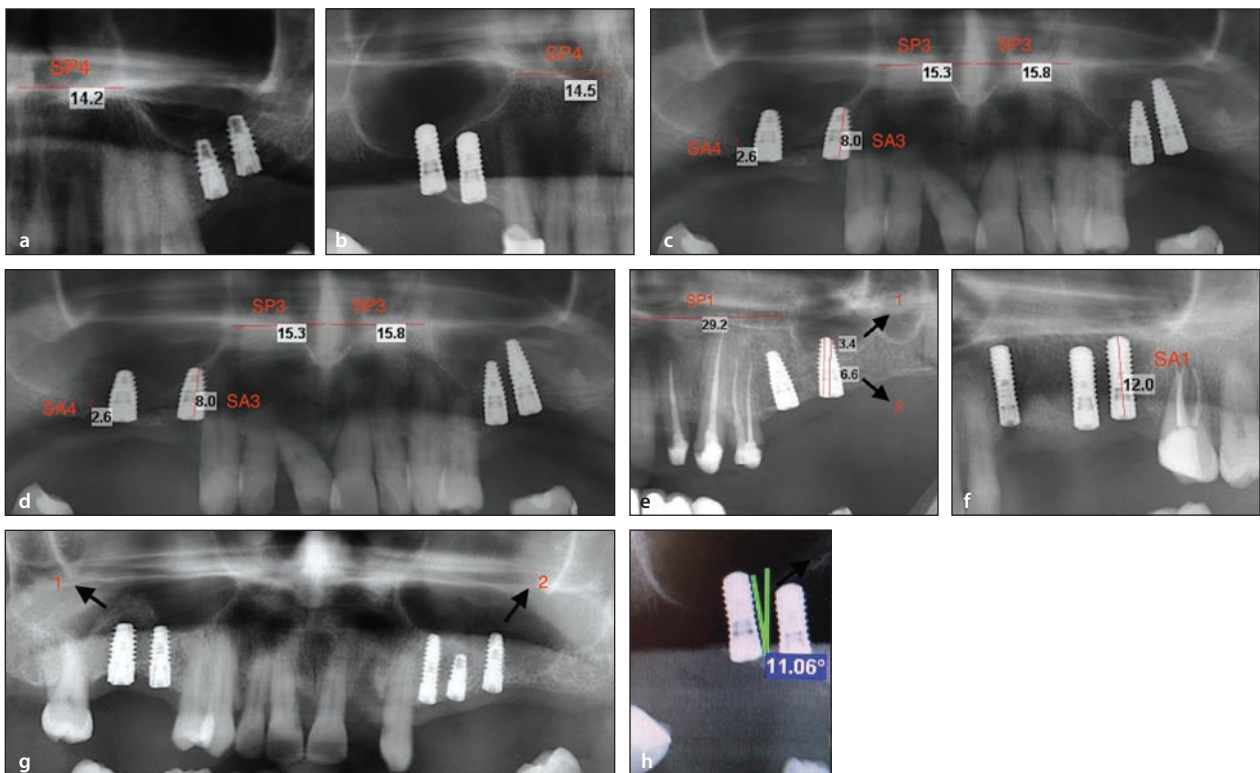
Inferior pneumatization of maxillary sinus and medial pneumatization of maxillary sinus are shown; the measurements (in millimeters) of the dental implants in bone and sinus were made from panoramic radiographs. (a) SA4 classification. (b) SA4 classification. (c) SP2, SP3, and SA2 classifications in the same patient, length measurements for dental implants. (d) SP3, SA3, and SA4 classifications in the same patient, length measurements for dental implants. (e) SP1 and length measurements for dental implants, 1: length measurement in the sinus, 2: length measurement in bone. (f) SA1 classification. (g) 1: External sinus elevation, 2: internal sinus elevation. (h) Angle measurement for dental implants; black arrow indicates the parallel line to the midline, whereas the other line indicates the axis of the implant.
